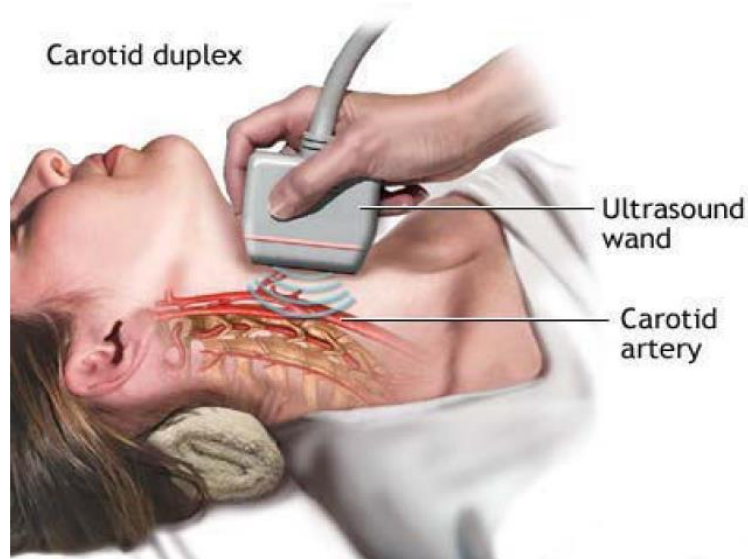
Sonographic Evaluation of Carotid Arteries
